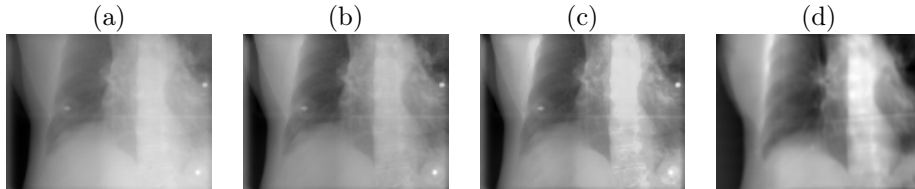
(a) A raw Cone-Beam (CB) projection (target projection), (b) a local Gaussian normalized CB projection (normalized target projection), (c) histogram matched CB projection (normalized and histogram matched target projection) and (d) a local Gaussian normalized DRR of a Fréchet mean CT (learning projection) from a lung dataset. As shown in the images, after normalization and histogram matching, the intensity contrast in the target projection becomes closer to that in the learning projection.
